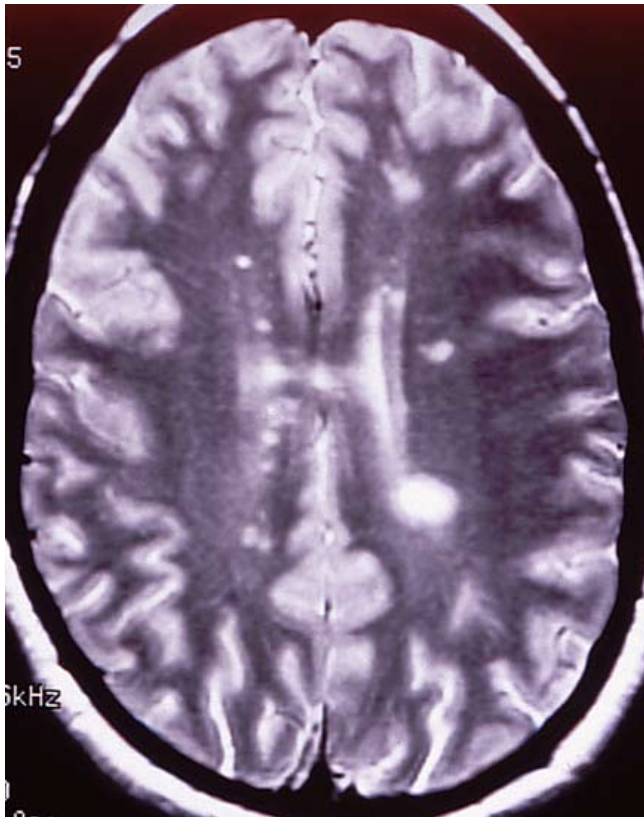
MRI in a case of multiple sclerosis
